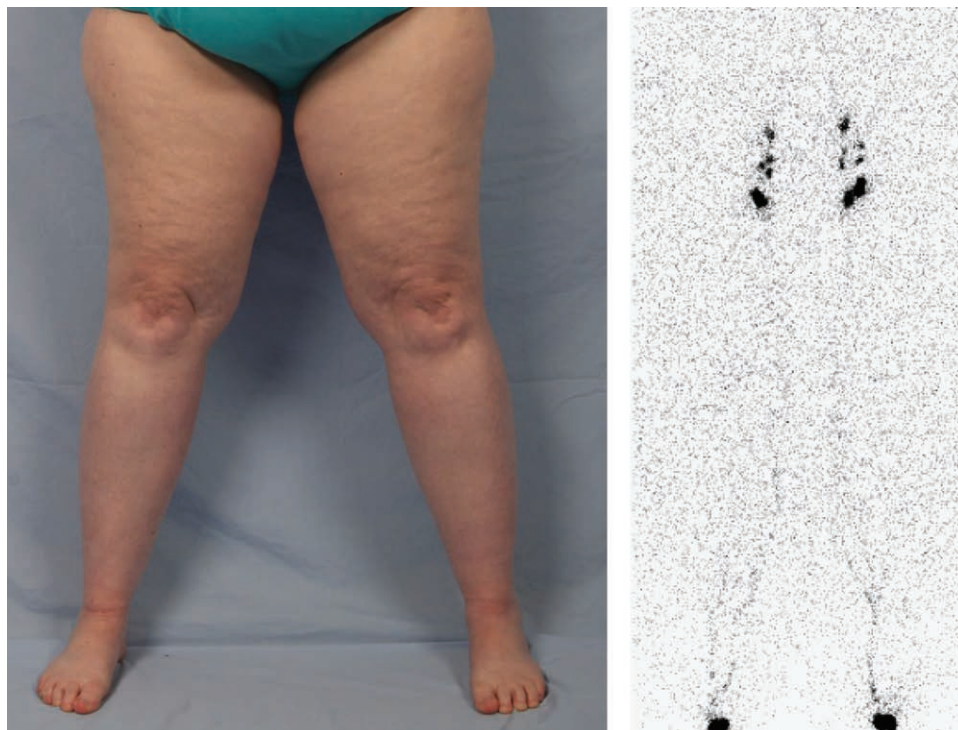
True-negative lymphoscintigram result. A 45-year-old woman was referred with a diagnosis of bilateral lower extremity “lymphedema.” Her history and physical examination, however, was consistent with lipedema and not lymphedema. Lymphoscintigraphy confirms normal lymphatic function (tracer in the inguinal nodes 45 minutes after injection and no dermal backflow).
